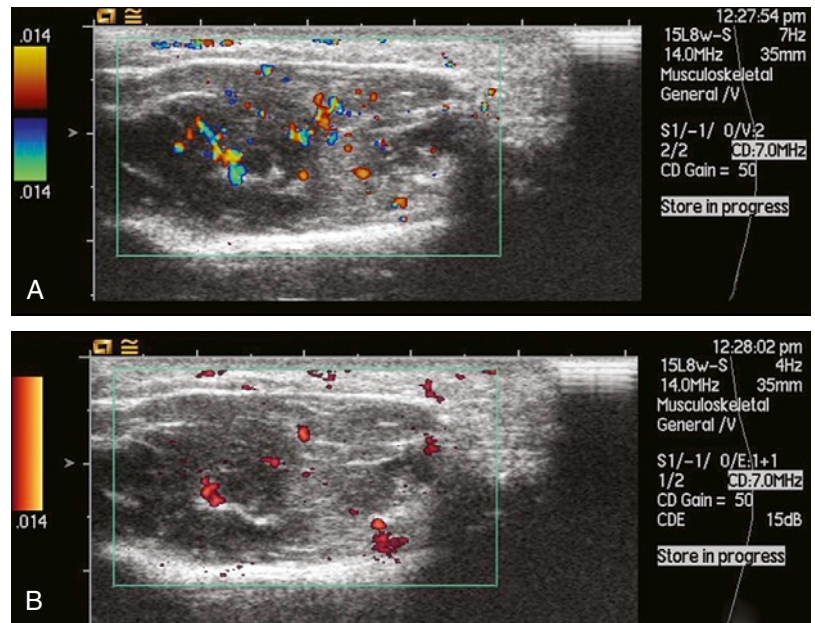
CHOICE OF DOPPLER MODALITY. A, Color Doppler shows the thenar muscle. B, Power Doppler shows the thenar muscle. On this machine, color Doppler provides the most flow information, but the parameters must be tested for each machine.
